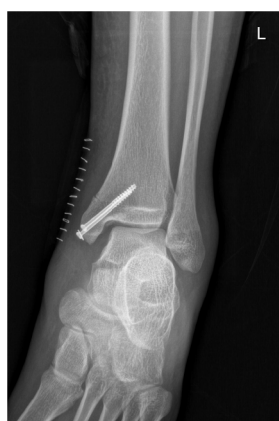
Postoperative radiograph showing the enlarged tibiofibular clear space and medial clear space.
